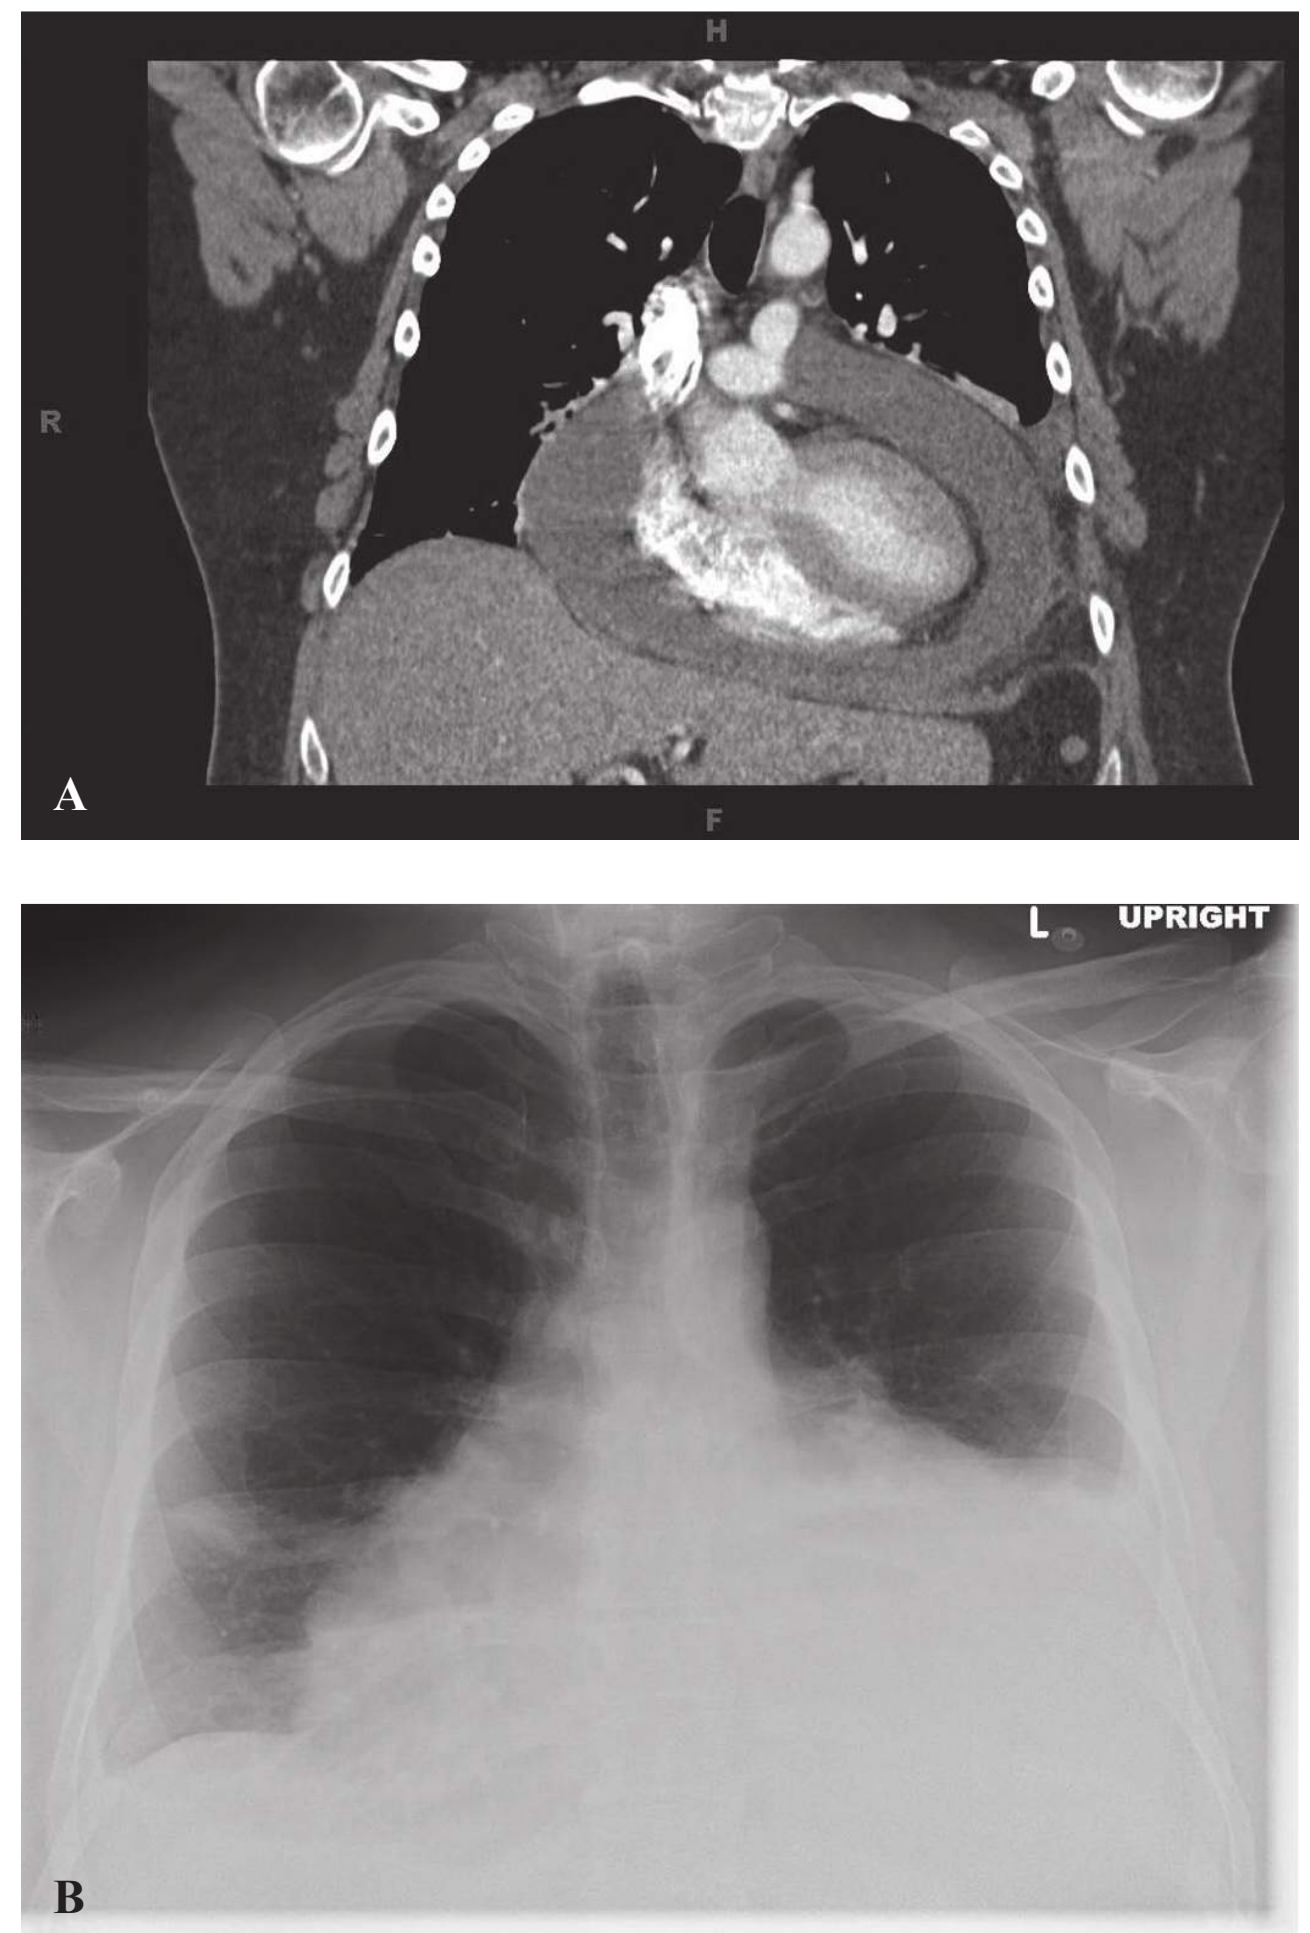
Chest radiograph (A) and CT (B) of an asymptomatic patient with a large idiopathic effusion.
